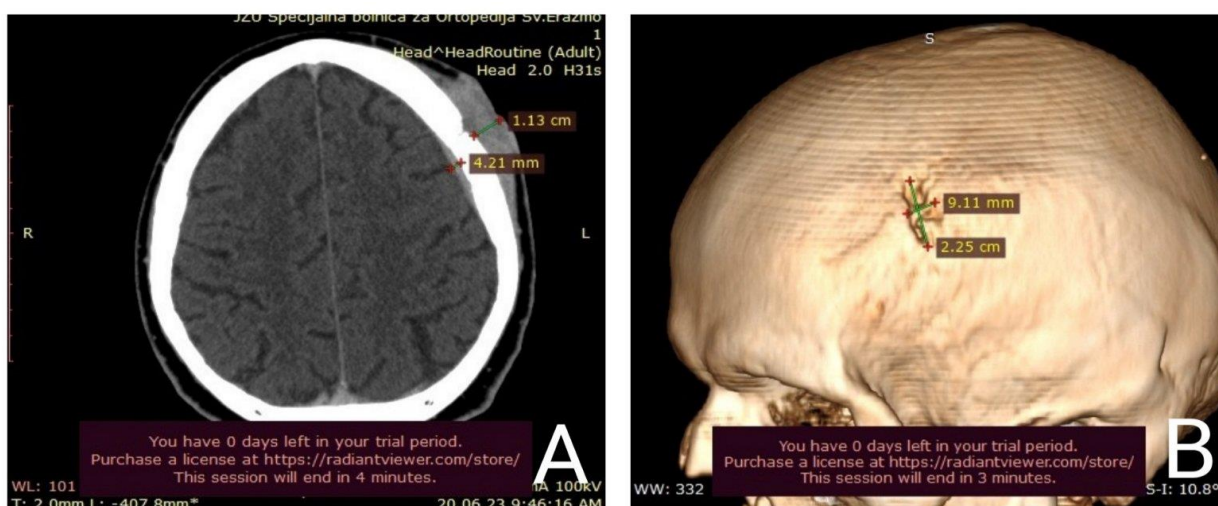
CT result of head and neck preoperatively shows an ulcerative soft tissue thickening on the left temporoparietal region with a thickness of about 1.13cm, and local dural thickening of a longer segment with a width of about 4 mm is also visible. Figure 2B. 3D CT result of head and neck preoperatively shows the parietal bone osteolysis, with dimensions 22x9mm.
